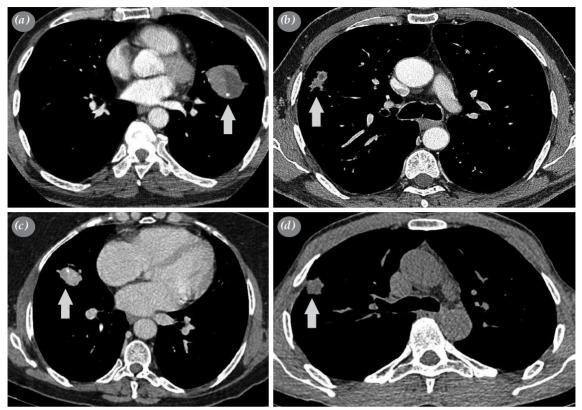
(a) Patient No. 13; left upper lobe mass with necrosis and calcification, (b) Patient No. 14; right upper lobe mass with irregular margins, (c) Patient No. 15: right middle lobe mass with calcification, (d) Patient No. 17: right upper lobe mass with pleural indentation. (Axial computed tomography images on mediastinal window, gray arrows show the masses).
